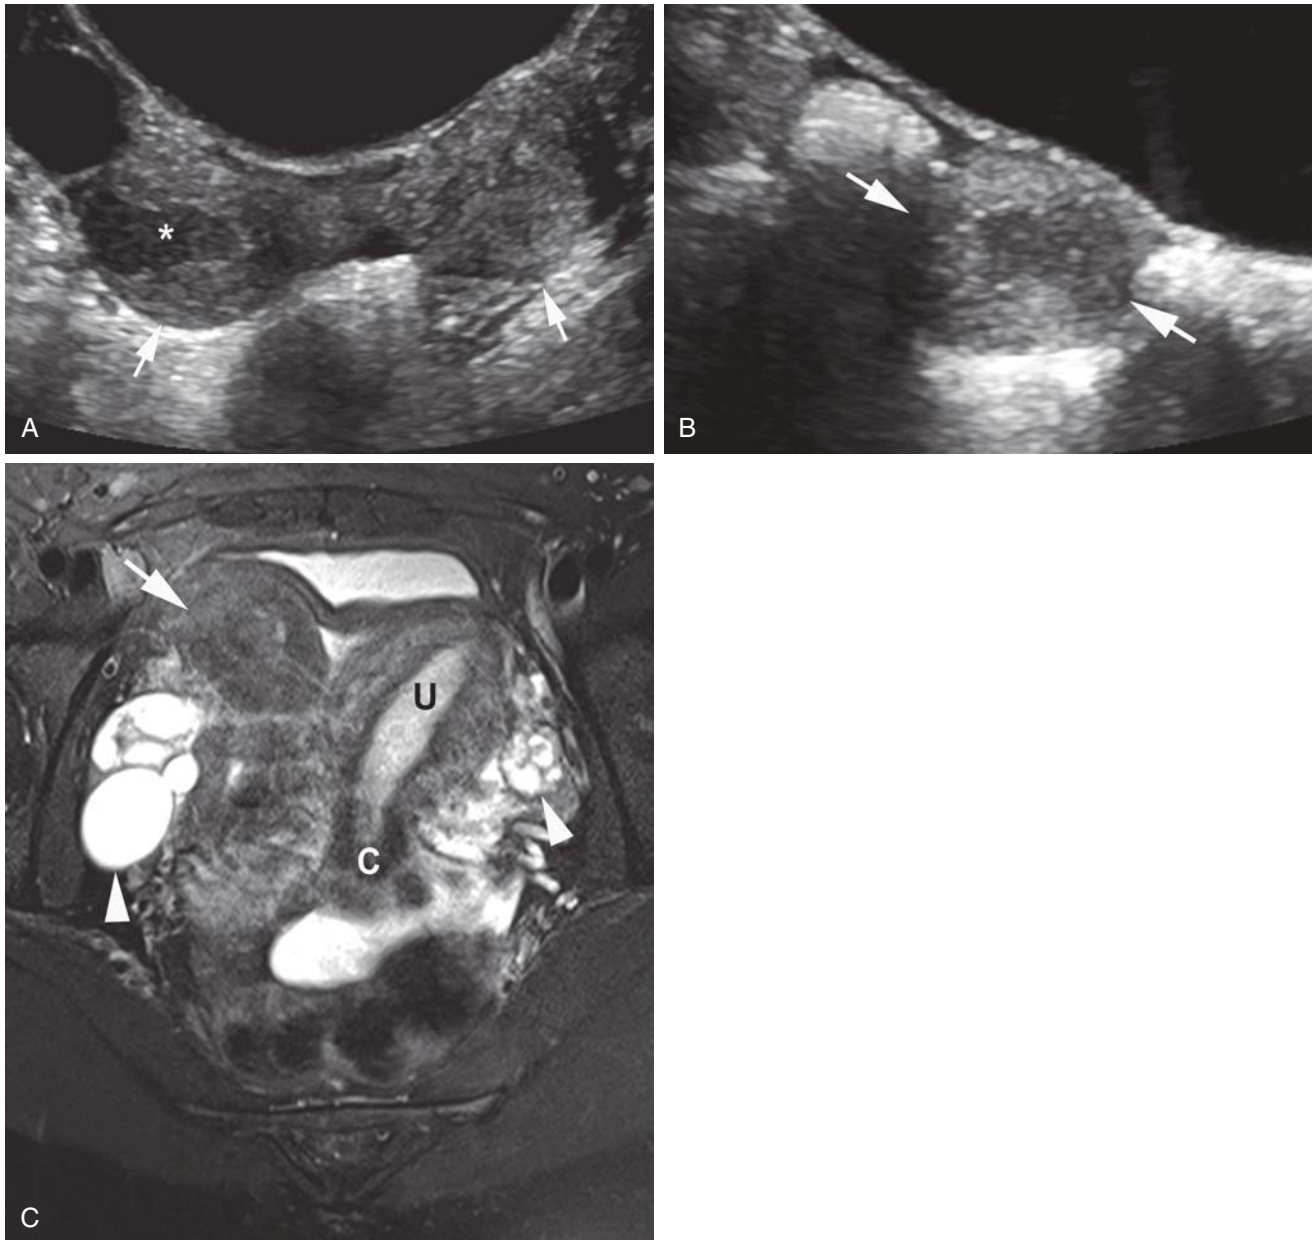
Unicornuate left uterus with an obstructed, rudimentary right hemiuterus in a 13-year-old girl with cyclic pelvic pain. A, Transverse ultrasound image reveals two uterine horns (*arrows*). Hypoechoic fluid distends the right uterine cavity (*asterisk*). B, Sagittal image depicts the truncated right hemiuterus (*between arrows*). C, Coronal T2-weighted magnetic resonance image demonstrates a well-developed left hemiuterus (U) and cervix (C). The smaller right hemiuterine cavity contains low signal intensity material compatible with blood products (*arrow*). Both ovaries contain normal follicles (*arrowheads*). The left vagina was normal (not shown). See Videos 34-1 and 34-2.
